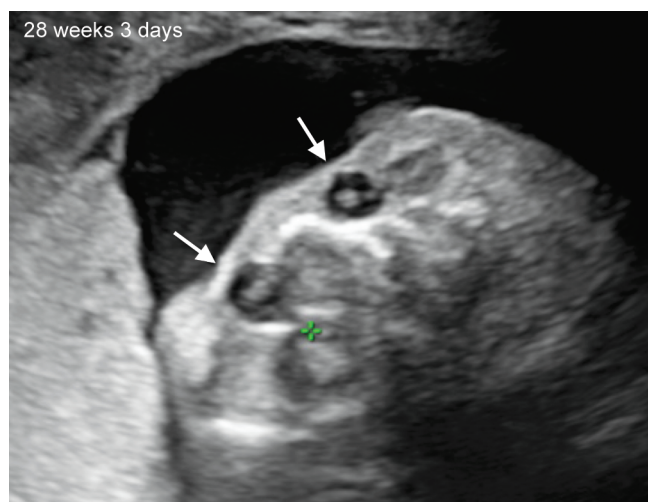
Two-dimensional sonographic images of bilateral congenital dacryocystoceles (arrows) at 28 weeks and 3 days of gestation
